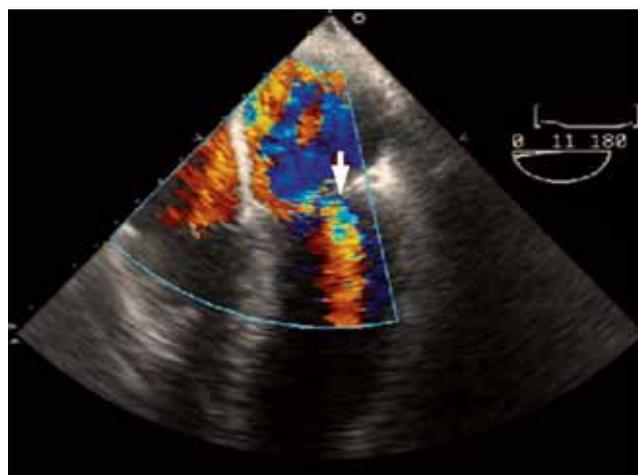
Anterior mitral leaflet flail and eccentric mosaic flow jet could be observed on echocardiography in the patient with an anterolateral papillary muscle rupture.
